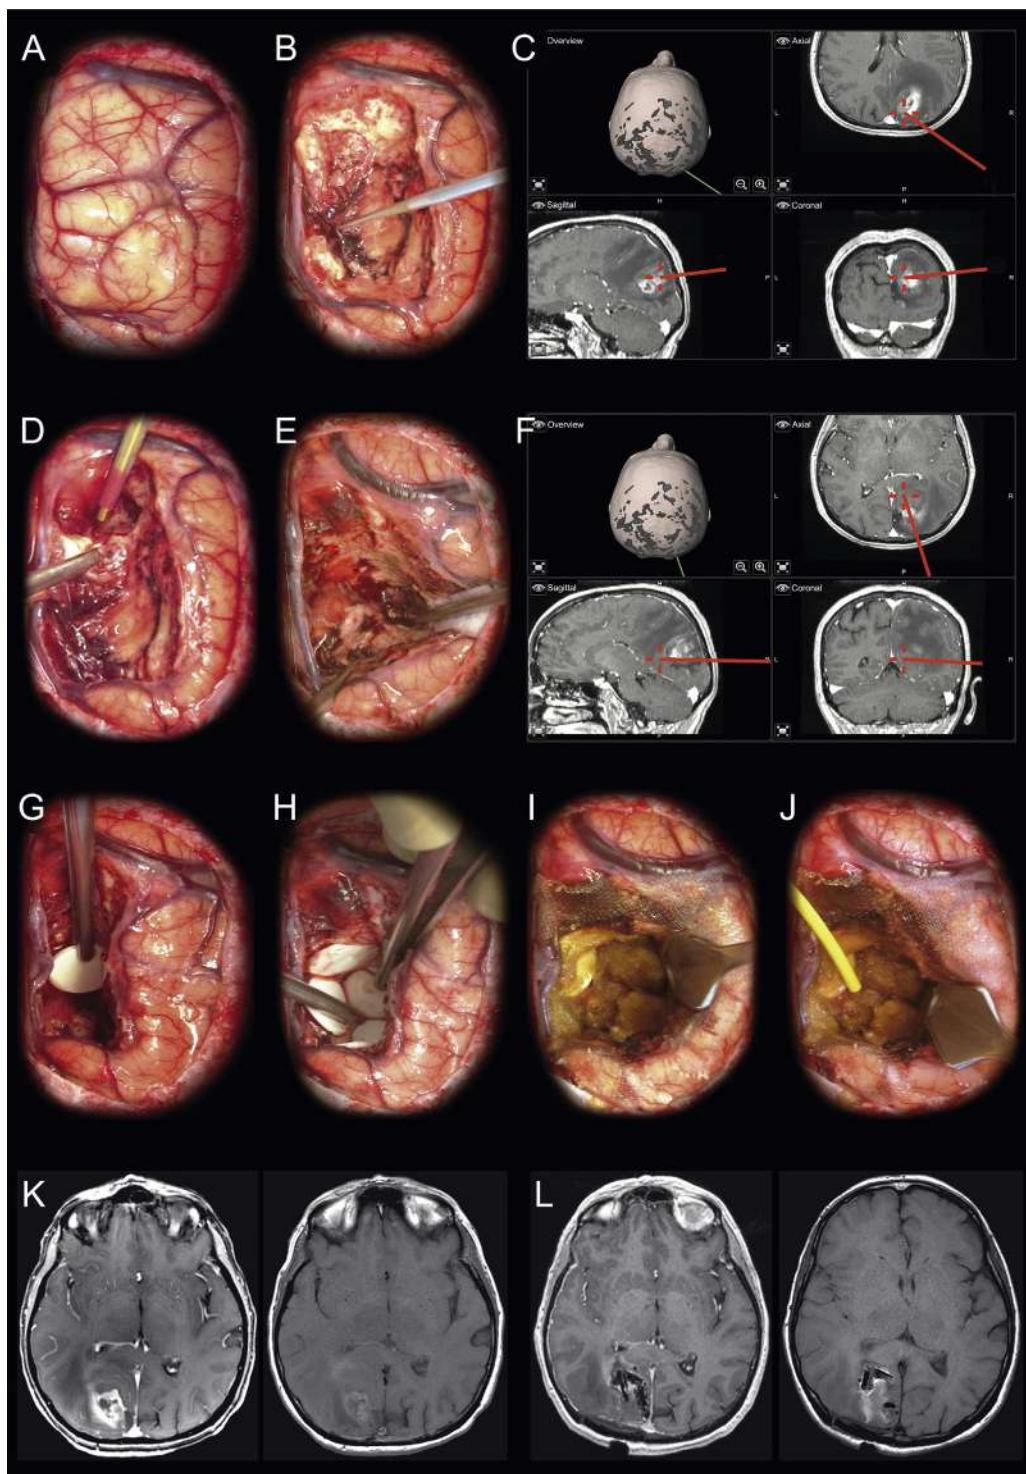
Carmustine wafer implantation in high-grade glioma surgery. Intraoperative photographs (A–J) showing the surgical field in an adult patient who underwent surgical resection with carmustine wafer implantation for a right parietal IDH-wildtype glioblastoma and corresponding preoperative (K) and postoperative (L) MR examinations. On opening the dura, the tumor infiltration component appeared cortically as pale, hypertrophied and distended gyri (A). After corticectomy, the contrast-enhanced tumor component appeared as dark red, purple and brown (B) as ascertained by the projection of the intraoperative tool on the MRI-based intraoperative neuronavigation system (C). A safe surgical removal was performed using an ultrasonic surgical aspirator (D) beyond MRI-defined abnormalities with preservation of functional boundaries (E), as ascertained by the projection of the intraoperative tool on the MRI-based intraoperative neuronavigation system (F). Then, after achieving hemostasis with no residual bleeding and removed every haemostatic material, carmustine wafers were implanted directly in contact with the brain surface (G) along the whole tumor bed (H). Carmustine wafers were then stabilized and secured by a single layer of cellulose absorbable hemostat (I) and covered by biological glue application (J). Preoperative (K) axial pre- (right) and post-contrast (left) T1-weighted sequence demonstrating a right parietal contrast-enhanced tumor. Postoperative day one (K) axial pre- (right) and post-contrast (left) T1-weighted sequence demonstrating the carmustine wafers lying over the surgical cavity. In (C) and (F) images, the side is reversed for navigation planning purposes.
